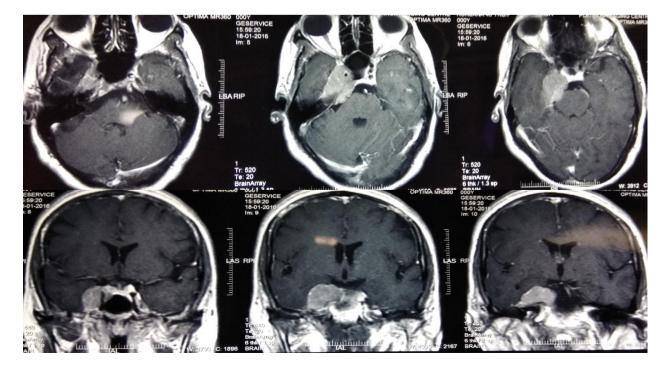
Contrast CT scan (coronal and saggital images) of patient done preoperatively 1 yr back, showing homogenously contrast enhancing lesion in right cavernous sinus.
